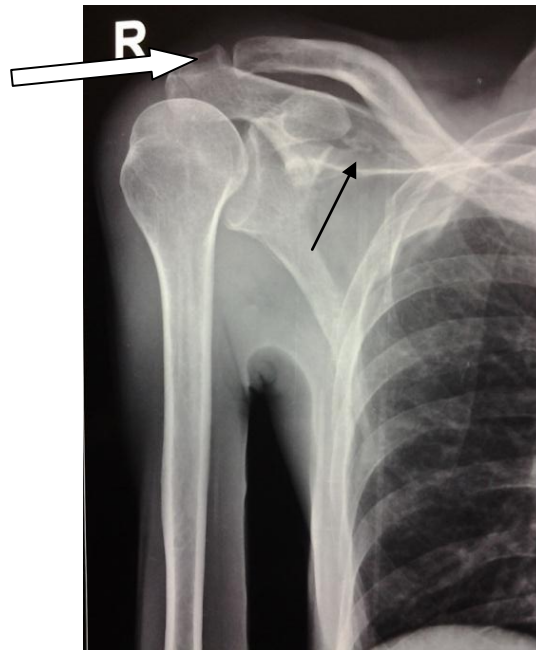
The patient's right shoulder radiograph. The white arrow marking the crack fracture of acromion. The black arrow pointing the avulsed small fragment of the upper border of scapula.
